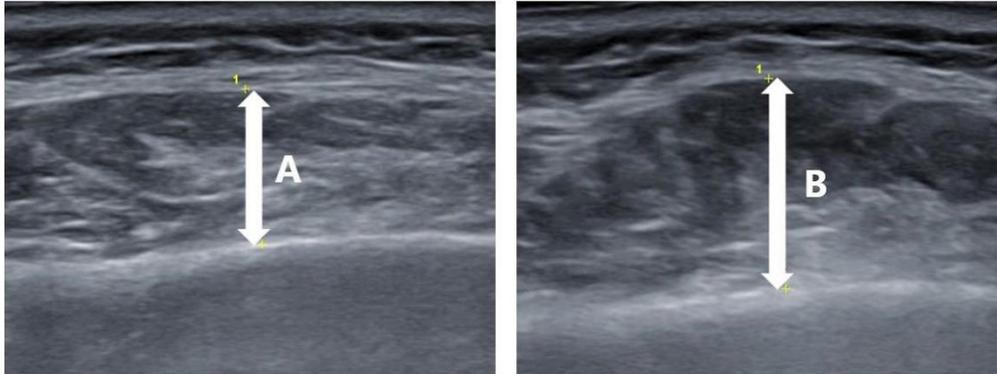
Masseter muscle images with ultrasonic diagnostic equipment
